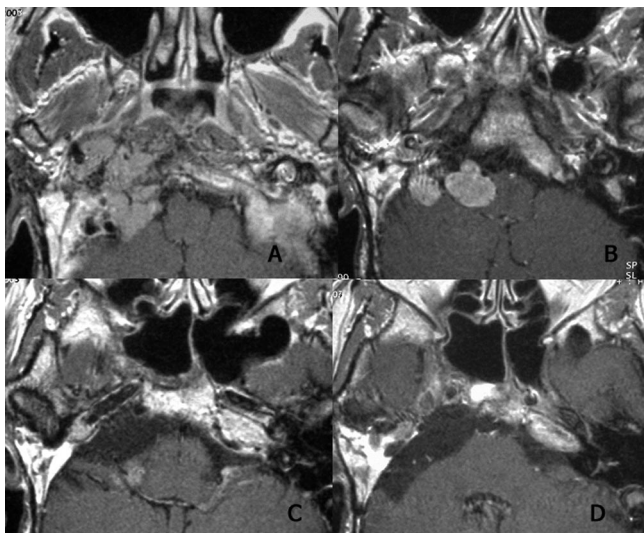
Axial Gd-enhanced magnetic resonance image showing encasement of the cervical (A) and petrous vertical (B) portions of the internal carotid artery (ICA). (C and D) Extension of the tumor along the horizontal portion of the petrous segment of the ICA.
